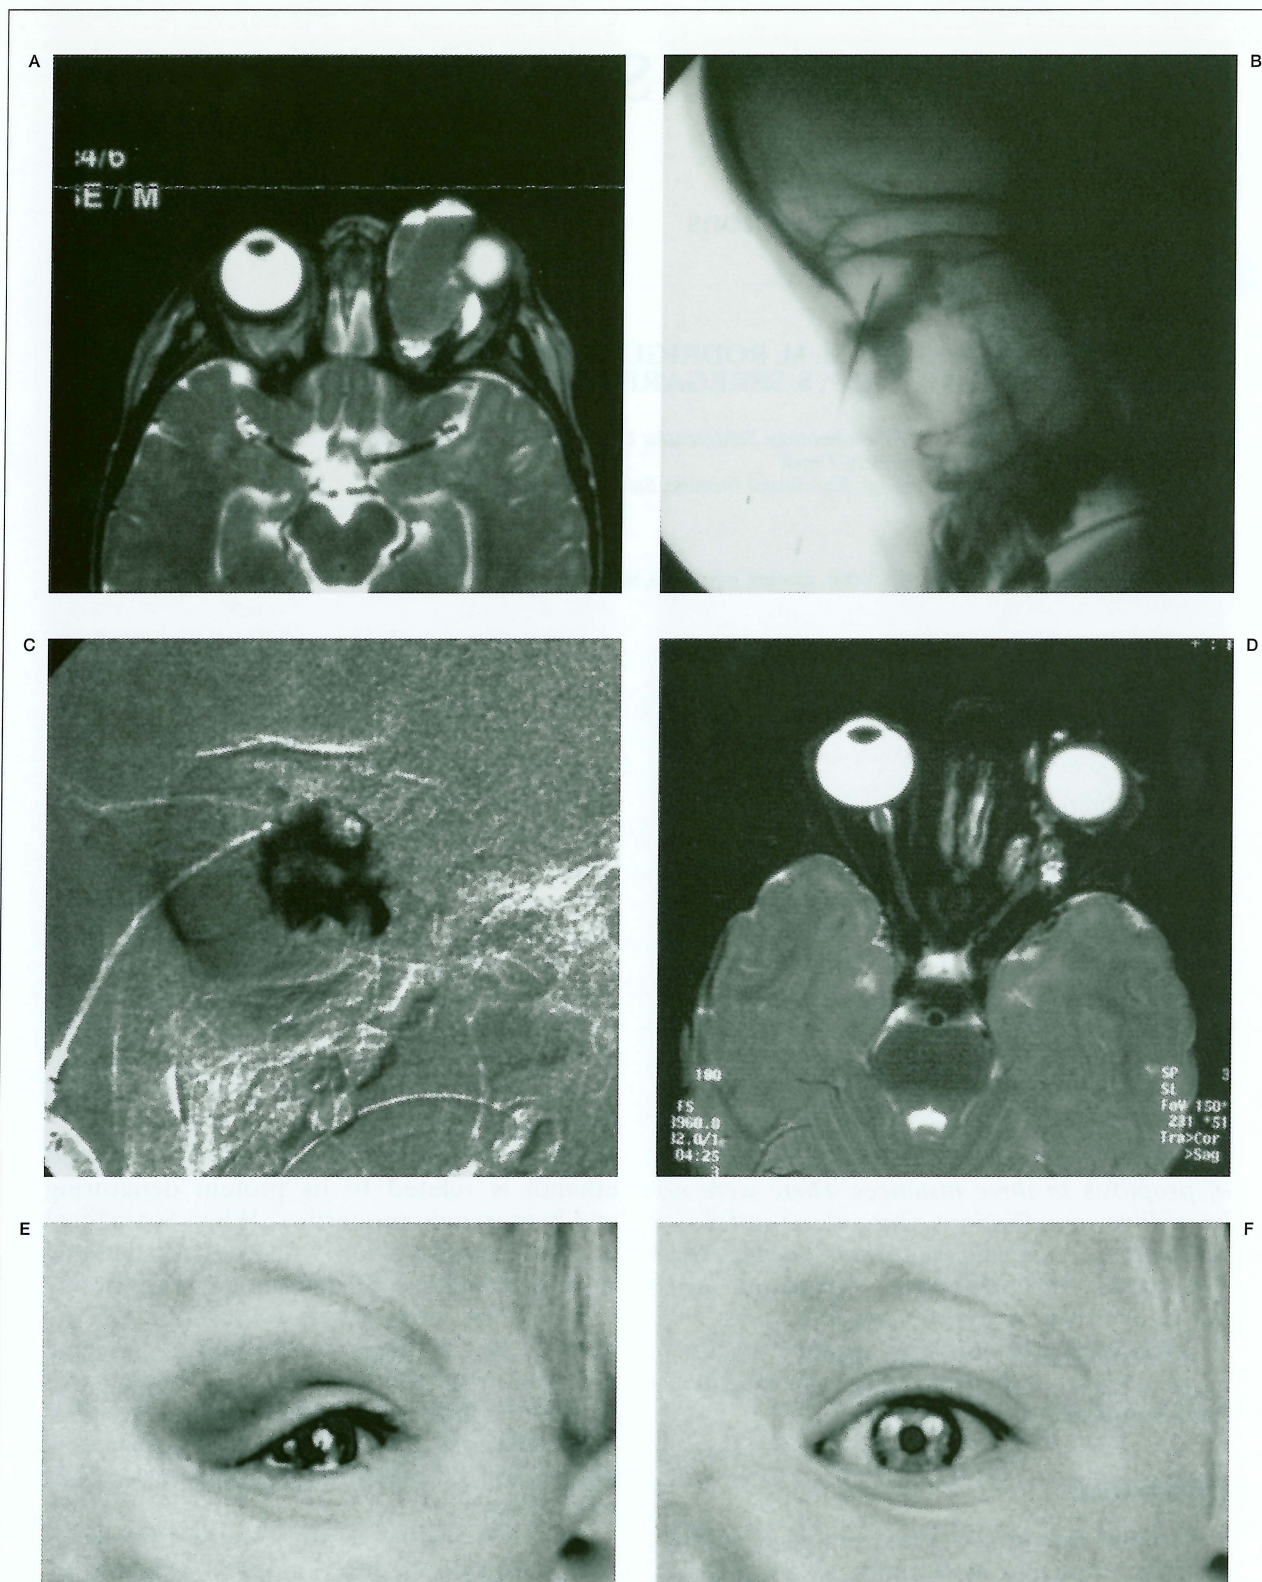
(Case 6) A small girl with moderate exophthalmos caused by a large lymphatic malformation. MRI before treatment showed large masses in the left orbit (A). Needle in position in the orbit (B). Road map of Sotradecol injected in the lymphatic mass medially in the left orbit (C). Compare A and B. Six months after the first injection the lymphatic masses are almost invisible at MRI (D). Compare A. Photographs before (E) and after treatment (F).
